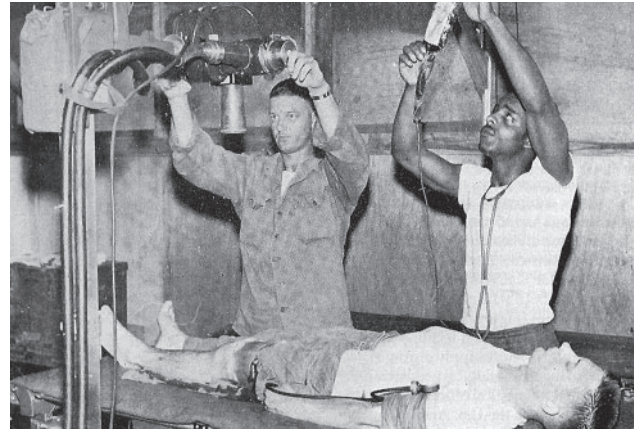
The x-ray section of a forward surgical hospital during the Korean War. The advances in x-ray technology and techniques that had been developed since World War II permitted field hospitals to practice quality imaging in their treatment of battlefield casualties.
